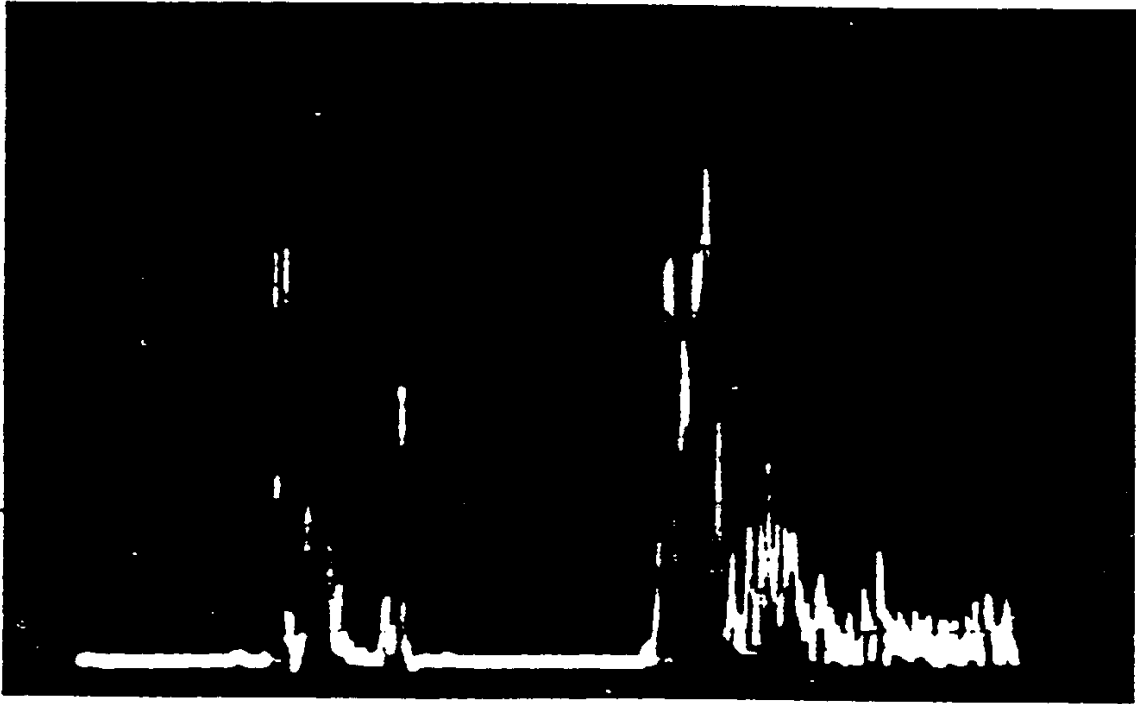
Ultrasonic A (amplitude) scan system.
